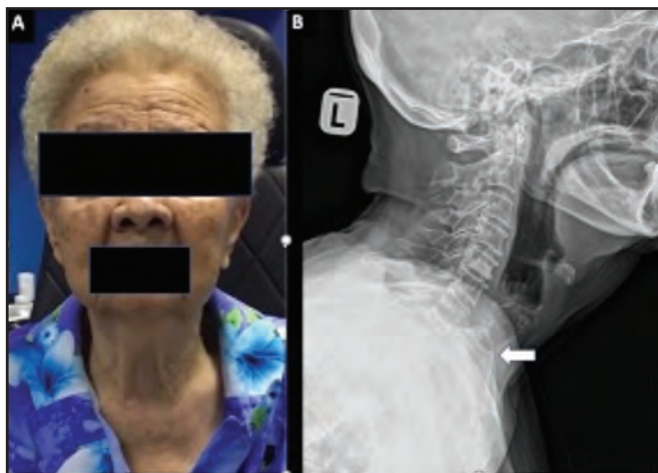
(A) Patient with a thin neck with no anterior neck swelling palpable (printed with consent). (B) Lateral neck x-ray showing a narrowed subglottic area at level C7 (white arrow)
